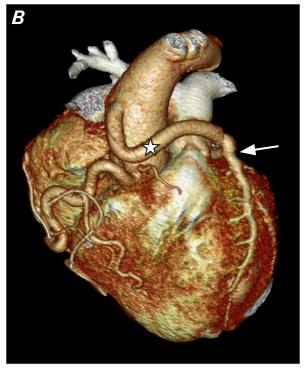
Multislice CT scan with contrast of the heart and great vessels. A) Presurgical CT scan shows anomalous left coronary artery (arrow) originating from the pulmonary artery. B) Postsurgical CT scan shows reimplanted anomalous left coronary artery (arrow) from the pulmonary artery in the systemic circulation. The star indicates the right coronary artery.
